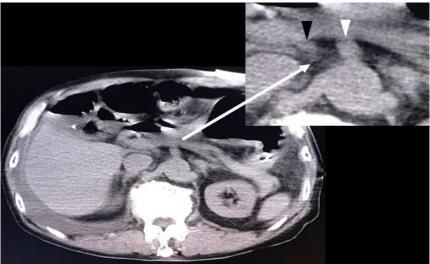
Abdominal CT on arrival
